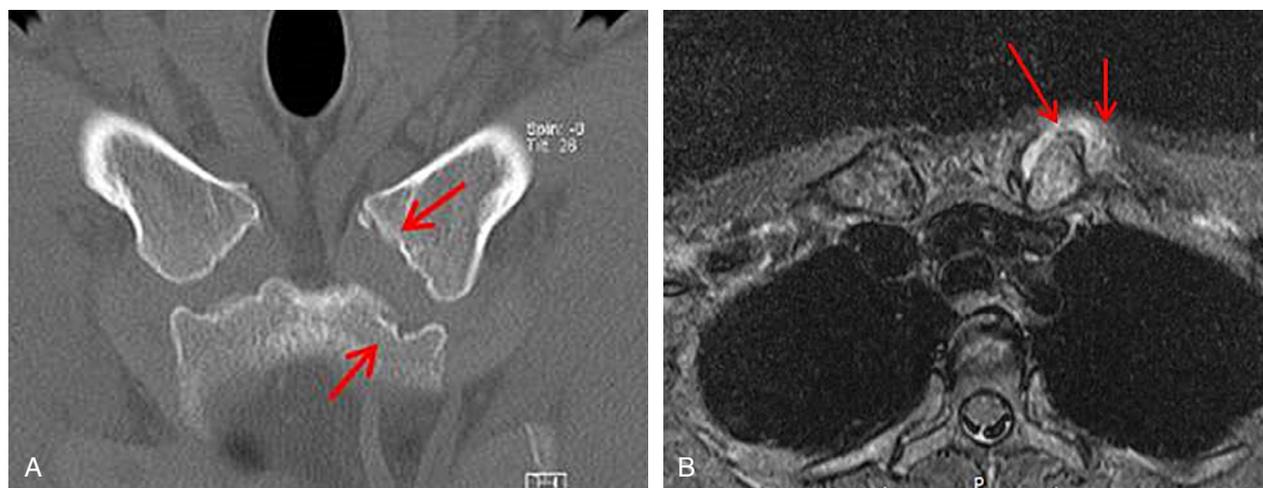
(A) Bilateral osteoarthritis of the SC joints, computed tomography scan, coronal plane; 24-year-old male patient. Notice the subchondral cysts that are present on both sides of the joint (*arrows*). (B) Axial magnetic resonance imaging (T2) of the chest in a 38-year-old woman demonstrating osteoarthritis of the left SC joint. Notice the increased signal intensity in the joint and periarticular soft tissues (*arrows*).
